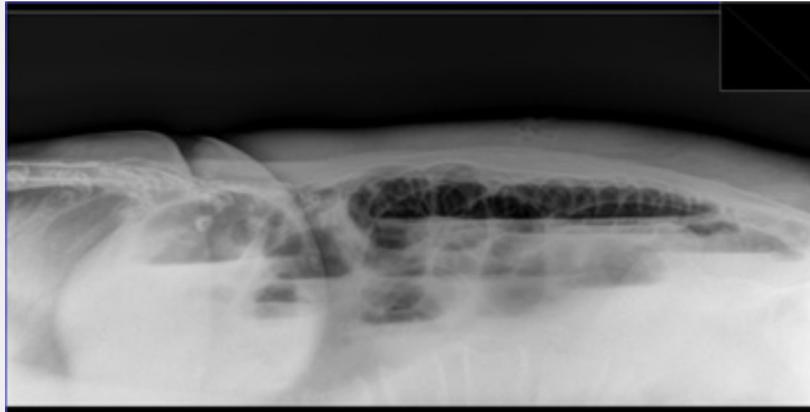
Abdominal X-Ray: Gas collections with multiple hydroaeric shadows.
